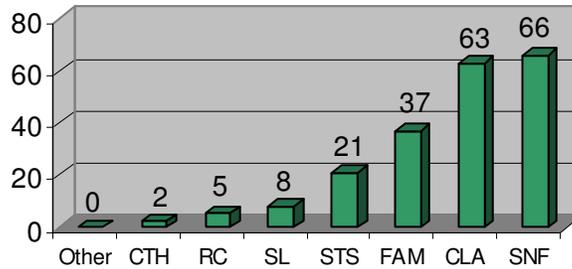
(above) depicts the actual number of deaths by where people live. In line with last year's data the greatest number of deaths occurred in skilled nursing facilities followed by CLA's, family homes and STS . Over 78% of the CT DMR population live in family/own home or CLA's.
